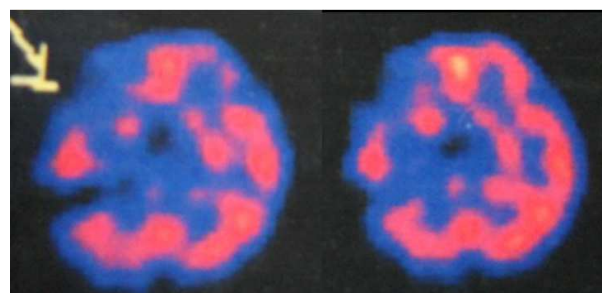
A, B SPECT before treatment: Hypoperfusion at frontal and temporal lobel.
